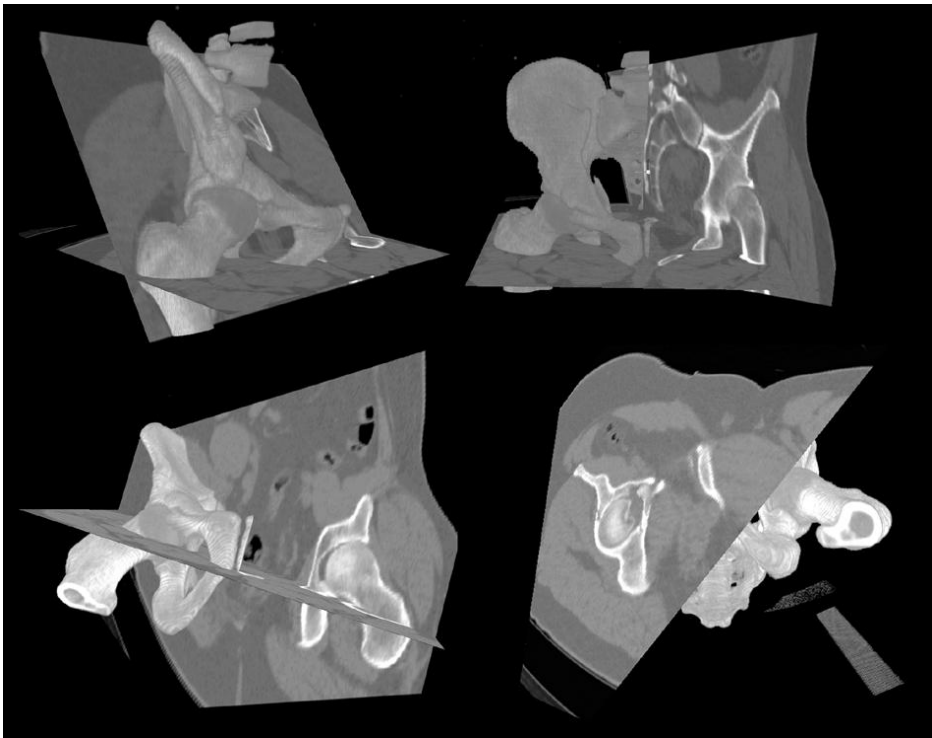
Acetabular Fracture: Presenting a computed tomography dataset within the virtual 3D scene. The original image data is volume rendered after a threshold has been applied. Arbitrary slice images can be visualized in addition, optionally clipping the displayed volume.
